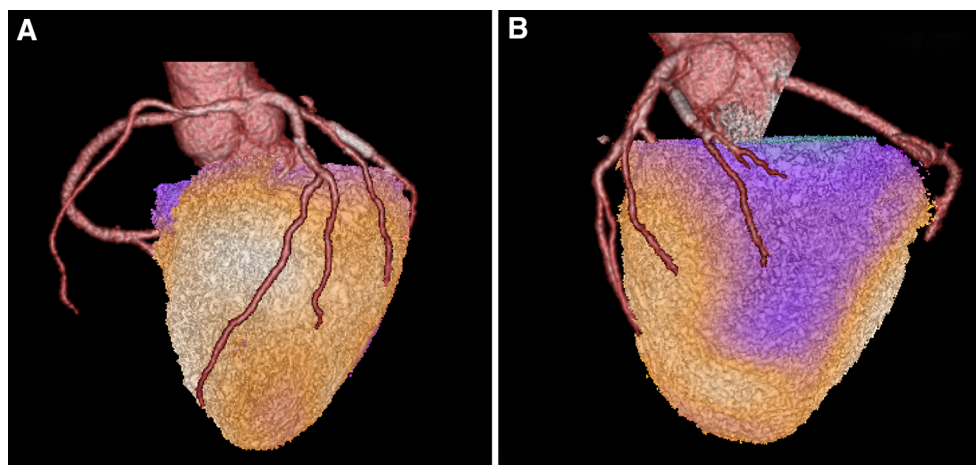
Hybrid CCTA/SPECT-MPI (using the CT attenuation-corrected rest dataset) shows a malignant ACAOS with the RCA originating from the LCS with an interarterial course. The inferolateral scar tissue could be clearly allocated to the perfusion territory subtended by the non-anomalous LCX which was previously revascularized with a stent due to occlusion and subsequent myocardial infarction (A, B).
